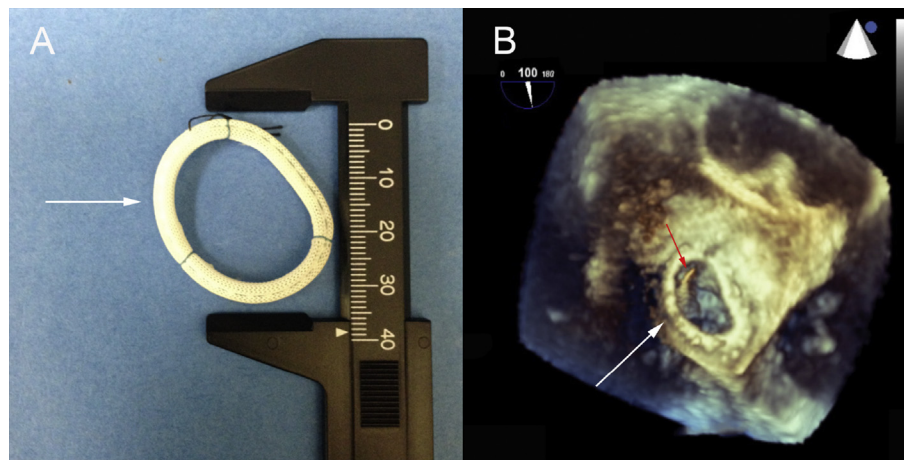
32 mm Carpentier-Edwards Physio Annuloplasty Ring. A) Ring oval morphology at baseline (arrow) and B) Pre-procedural 3D Transesophageal echocardiogram with oval mitral ring (white arrow), diameters of 21 mm by 29 mm and a wire crossing the valve (red arrow).
